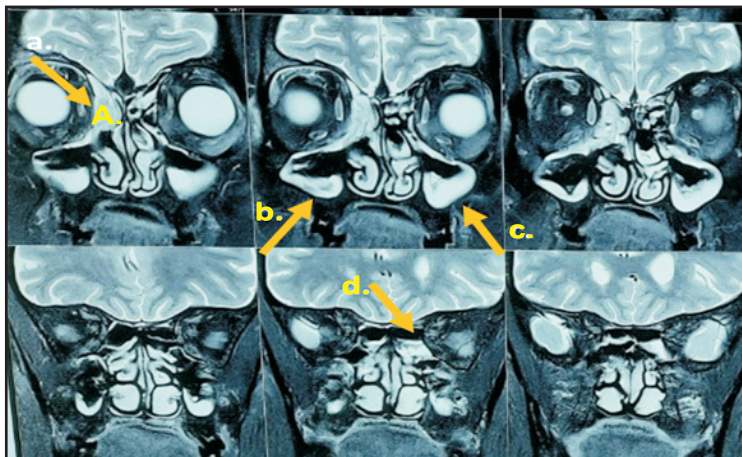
T2 weighted MRI paranasal sinus image in coronal section showing (a) heterogenous signal in right ethmoidal and supraorbital air cells suggestive of fungal elements; mucosal hypertrophy in (b) right and (c) left maxillary sinuses; (d) hyperintense signal in left sphenoid sinus suggestive of mucosal hypertrophy.
